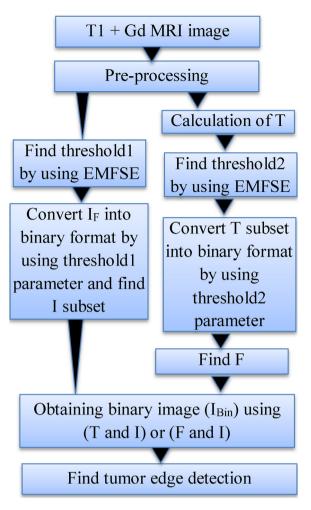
Converting NS domain of MRI image by using NS-EMFSE.
